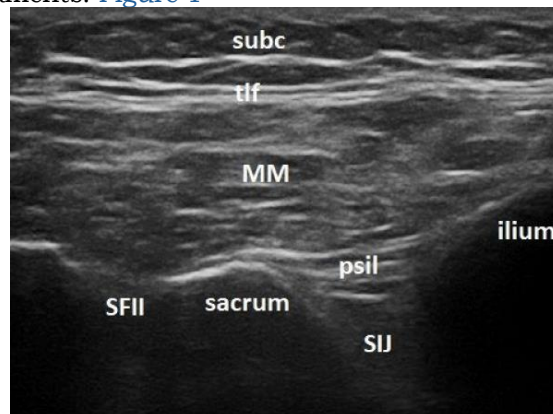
Short-axis sonogram showing (SIJ –
